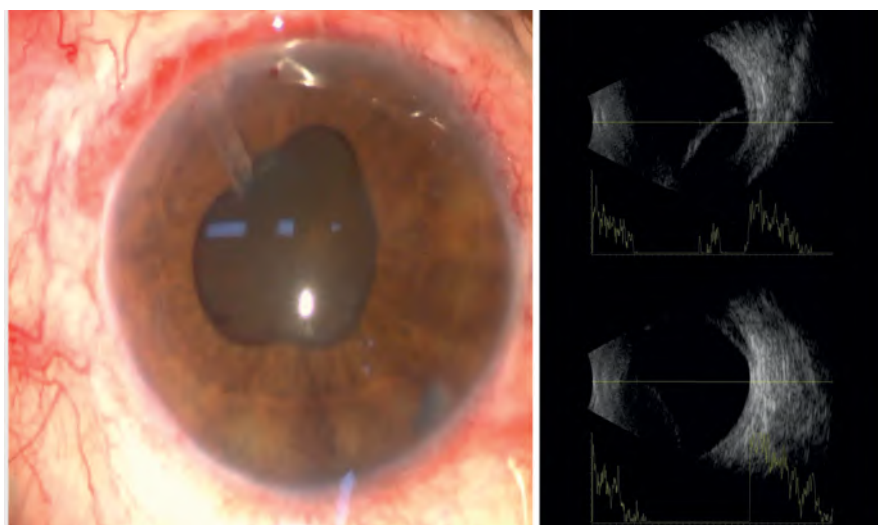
Ocular examination revealed shallow AC, direct contact between the tube end and the iris, and an edematous, swollen lens with posterior synechiae. An accompanying ultrasound image shows a choroidal detachment
